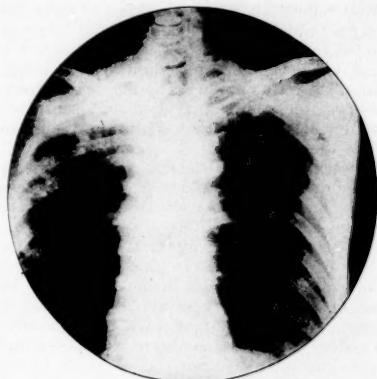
X-ray of chest showing foci of infiltration and areas of calcified processes not unlike pulmonary tuberculosis.
